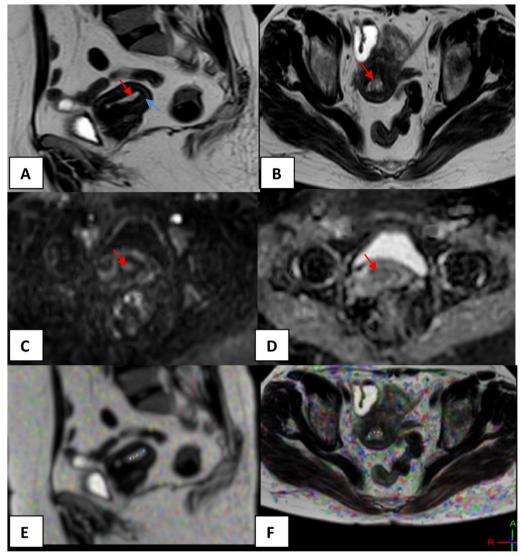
A 55-year-old postmenopausal female presented by abnormal vaginal bleeding. A, B *Sagittal and axial T2 WIs* irregular endometrial thickening which is occupied by a soft-tissue mass displaying intermediate SI (red arrow). No visible tumor breaching through the junctional zone (blue arrow). C *Axial DWI with b value of 1000 s/mm*² high signal intensity of the endometrial soft-tissue mass (red arrow). D *Axial DW-ADC map image* low signal intensity of the endometrial soft-tissue mass (red arrow). Mean DW-ADC value = 0.854×10^{-3} mm²/s. E, F *Sagittal and axial DTI map images*: values of DT-FA and DT-ADC (MD) in multiple ROI along the endometrial mass. Mean DT-FA value = 0.264, and mean DT-ADC (MD) value = 0.831×10^{-3} mm²/s. *Diagnosis* Pathologically proved endometrioid adenocarcinoma G2
